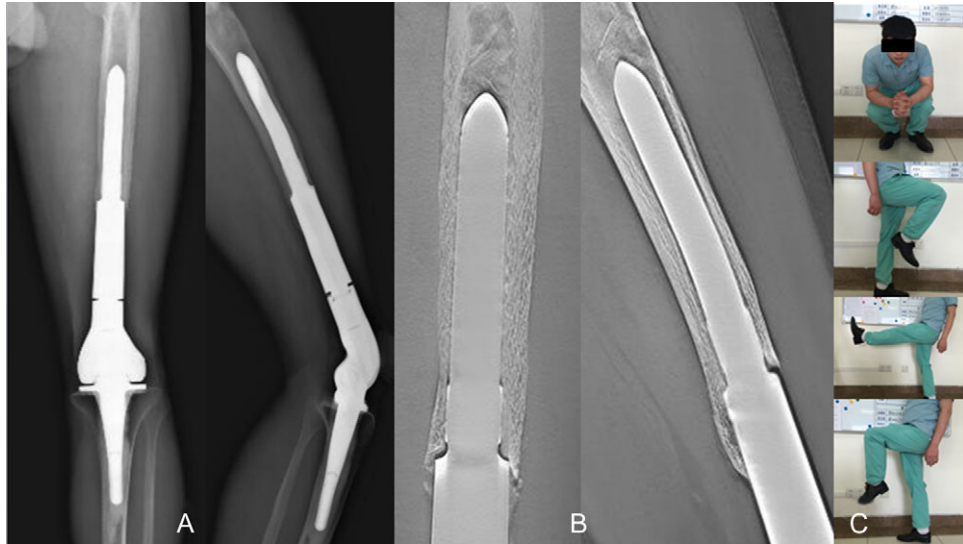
The radiographs and function of Patient 1 at 3.5 years follow-up after the revision surgery. (A) anteroposterior and lateral radiographs; (B) the T-SMART images show the implant osteointegration; function photos show the patient has a good knee range of motion.
